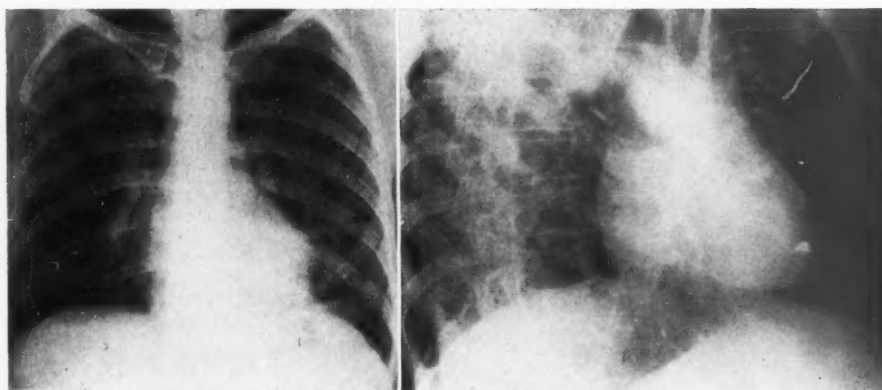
Left*. Case 5. Postero-anterior chest roentgenogram demonstrating a small aneurysm of left ventricle at site of entrance of the shell fragment. The fragment is not visible as it is superimposed over the vertebral column.
